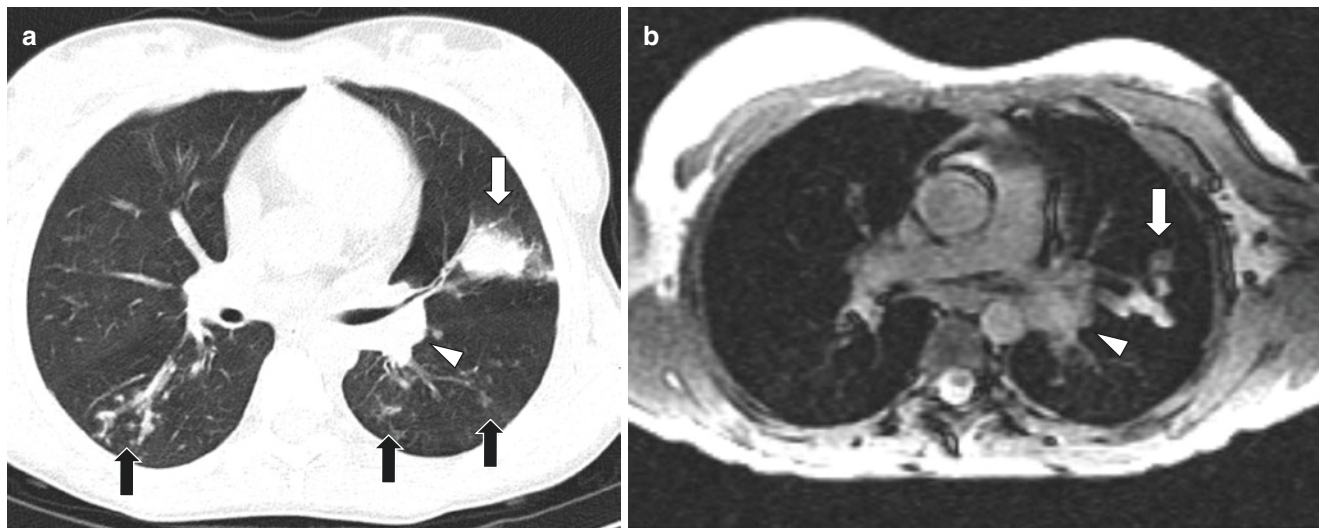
Pulmonary *Aspergillus* infection in 14-year-old girl with cystic fibrosis. (a) Axial enhanced lung window setting CT image shows tree-in-bud nodularity (*black arrows*) in bilateral lower lobes, a larger nodule (*white arrow*) with ground-glass halo in the left upper
